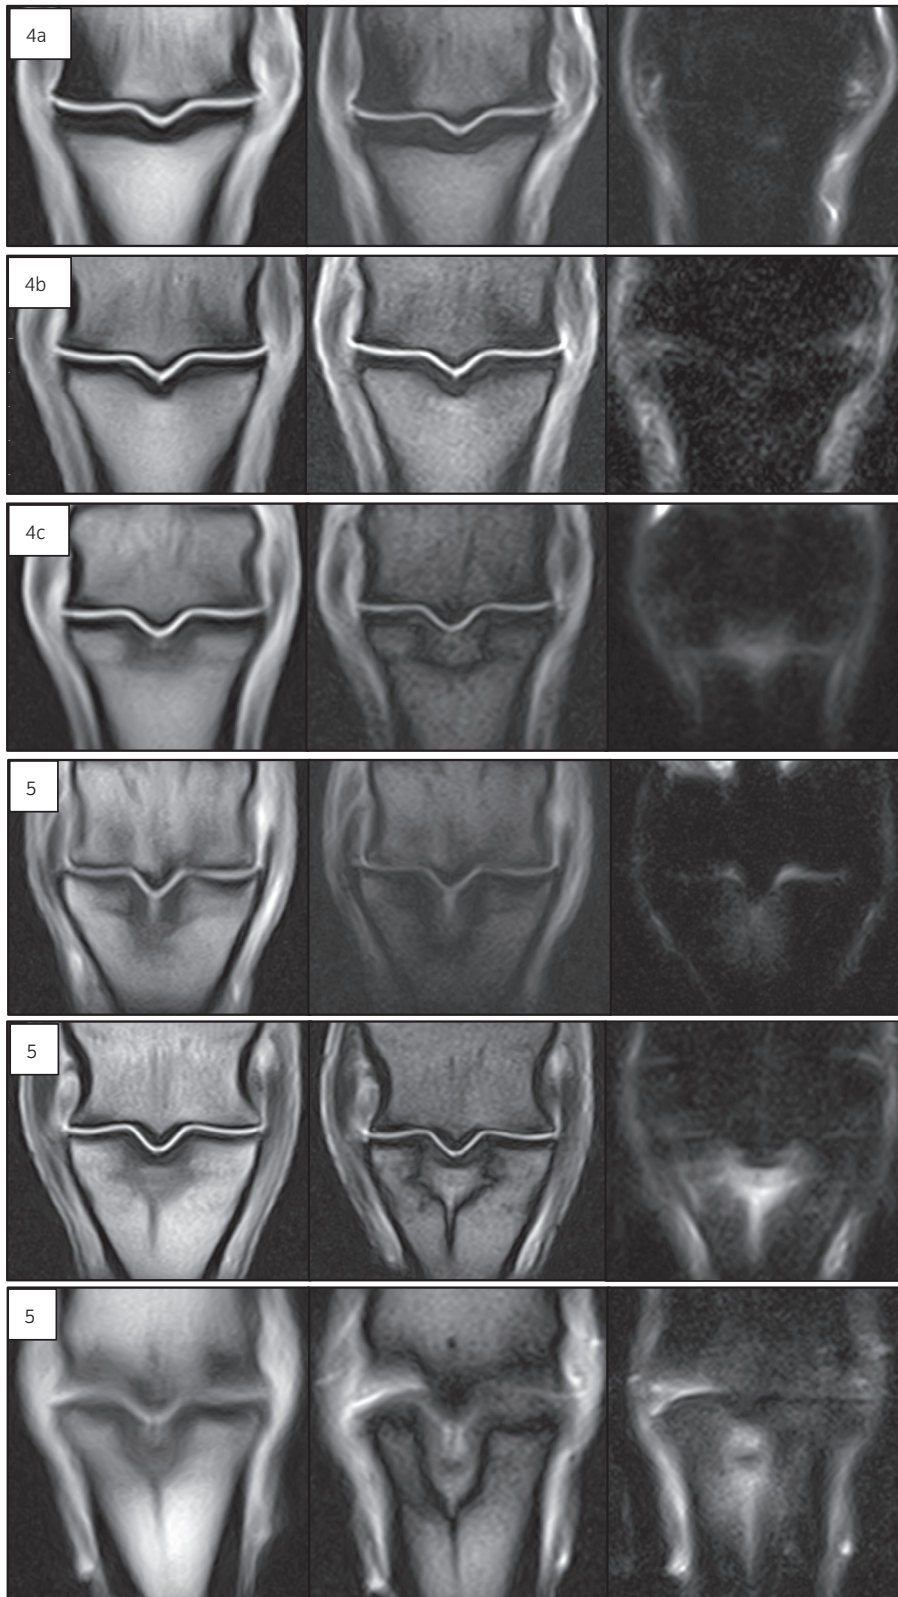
Example images of sagittal groove disease magnetic resonance imaging classification types 4a, 4b, 4c and three variants of 5 in T1W GRE frontal (left), T2*W GRE frontal (middle), STIR FSE frontal (right) planes. The first two variants of classification 5 have a unipartite configuration and the third has a tripartite appearance. STIR FSE, short tau inversion recovery fast spin echo; T1W GRE, T1-weighted gradient recalled echo; T2*W GRE, T2-weighted out-of-phase gradient recalled echo.
